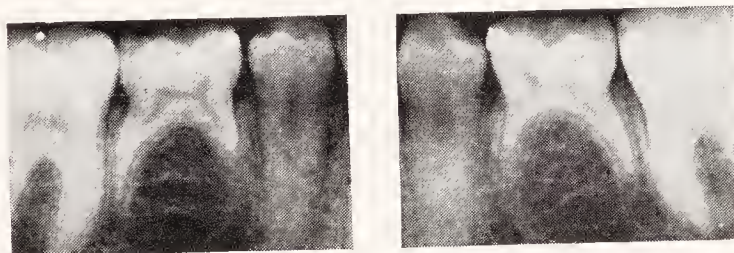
Radiographs of a child, aged thirteen years, with retained lower deciduous molars. No second bicuspid are present. The roots appear to be considerably shortened by resorption. (Courtesy of G. E. Morgan.)
